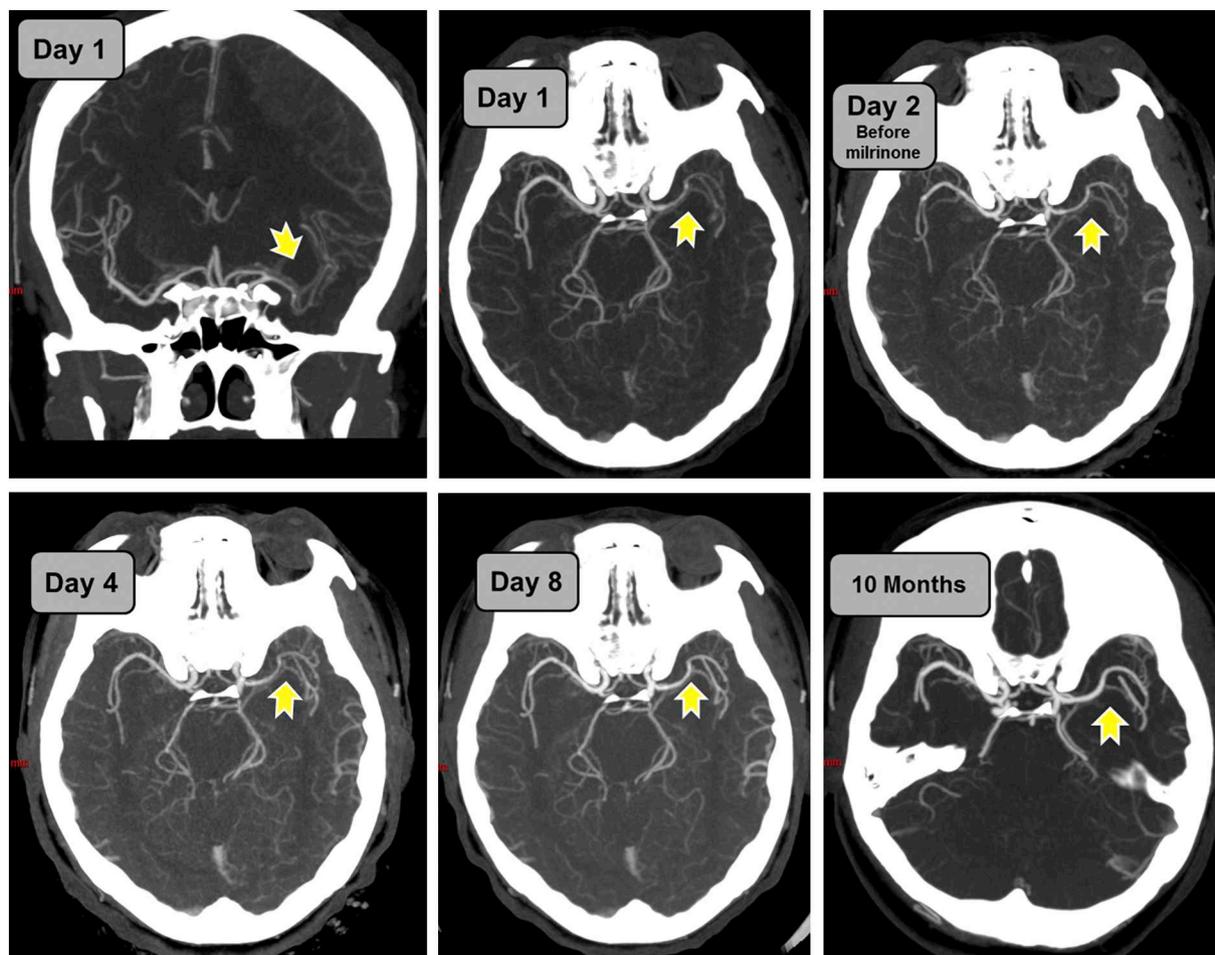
Coronal and transverse CT images at day 1 (hospital admission) displaying diffuse vasospasm (with segmental narrowing) of the left middle cerebral artery (MCA) and its branches. Intravenous nimodipine was initiated. At day 2, the vasospasm of the left MCA remained stable but a vasospasm of the right MCA occurred. Milrinone has been administered. Subsequently, the vasospasm aspect gradually vanished (CT images at day 4, 8 and 10 months after).
